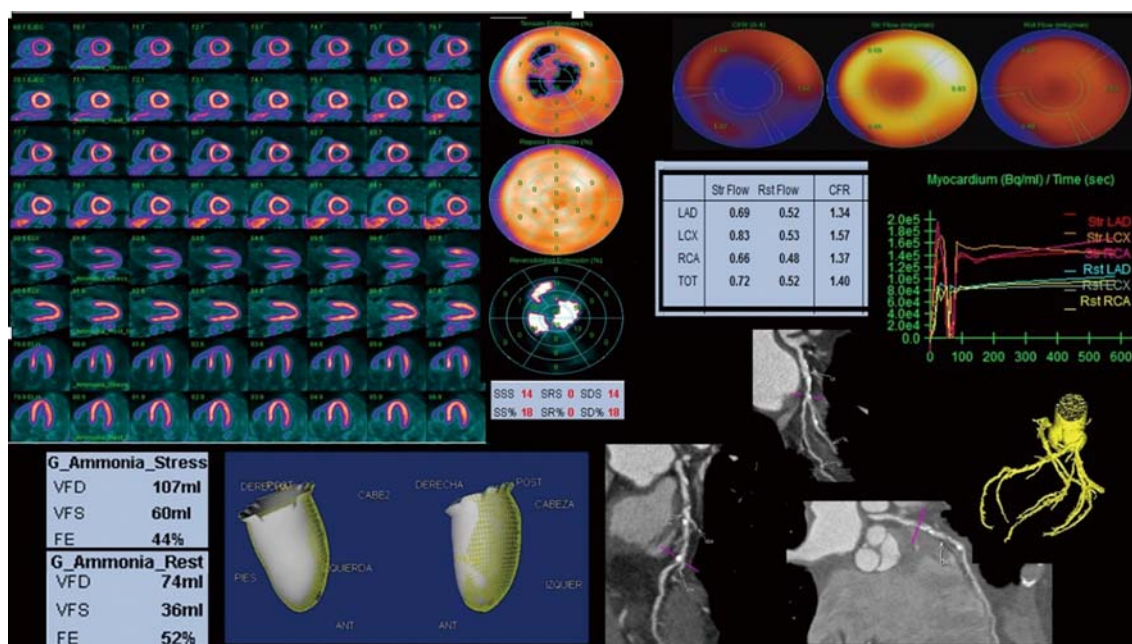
^{13}N -ammonia PET/CT. Abnormal myocardial perfusion study. Splash and polar shows moderate ischemia on the anterior wall, anterolateral segments and apex with SDS of 18%. Mild systolic dysfunction with an ejection fraction of 52% on rest, that decrease up to 44% on stress. Global hypokinesia. Abnormal flow quantitation: Rest MBF, 0.52; stress MBF 0.72; MFR, 1.40. CCTA with multiple calcified plaques conditioning significant obstruction on the left coronary artery (left anterior descending artery and the circumflex branch) and on the right coronary artery. Multivessel disease was confirmed.
